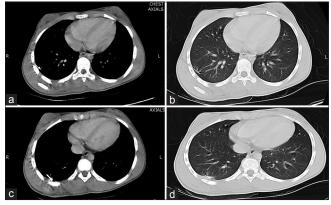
(a) Axial chest computed tomography, mediastinal window demonstrates the linear metallic density structure embedded within the right lung base. (b) Axial chest computed tomography lung window demonstrates the linear metallic density structure embedded within the right lung base with the entry track shown is noted within the right posterolateral chest wall. (c and d) Axial chest computed tomography mediastinal and lung windows demonstrate the linear metallic density structure embedded within the right lung base.
